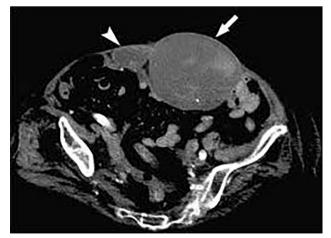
Abdominal computed tomography of a 65 years old woman with a history of mitral valve replacement of warfarin treatment at INR value of 3,74. Arrow shows the bilateral hematoma; the hematoma is bilateral that dissected between the transversalis fascia.
